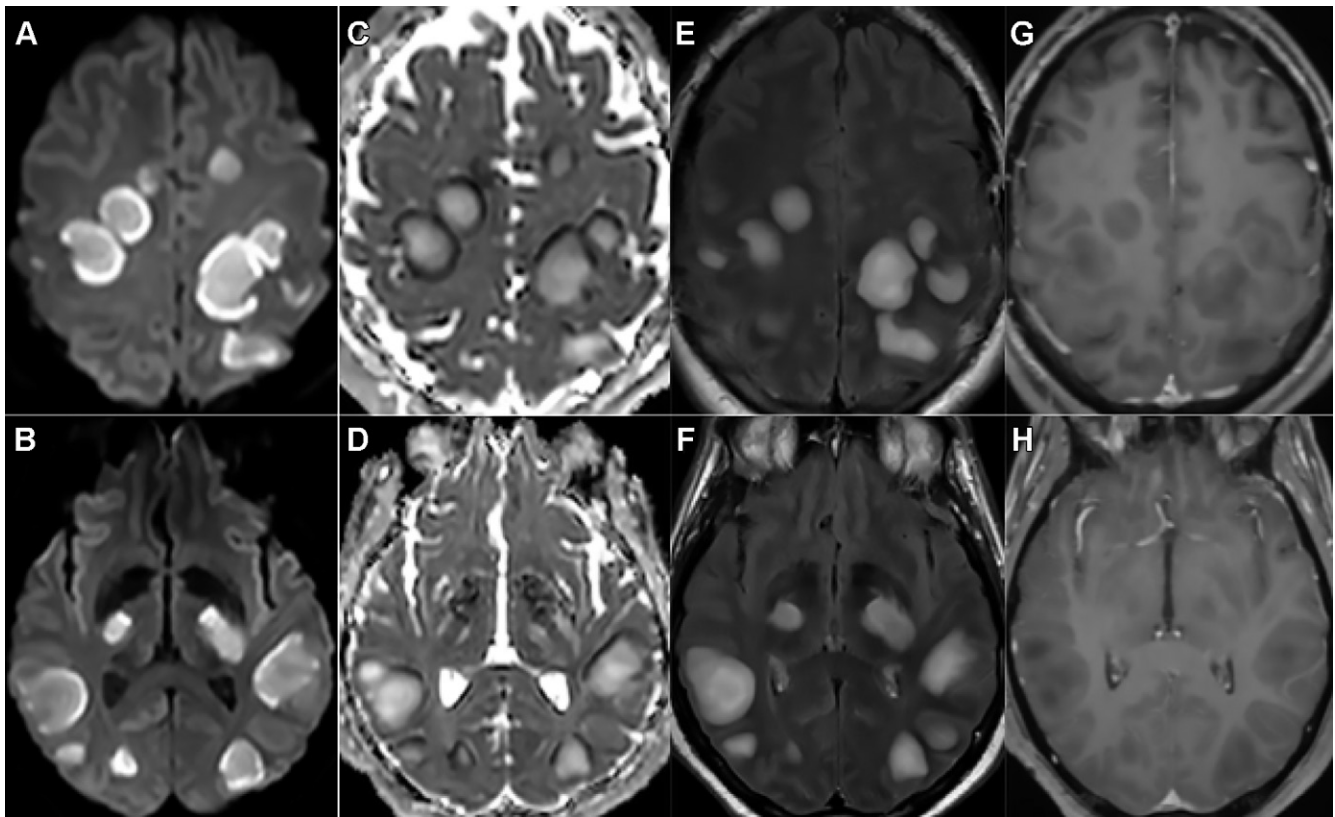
Images in a 54-year-old man with abnormal wakefulness after sedation. Nonconfluent multifocal white matter hyperintense lesions on fluid-attenuated inversion recovery (FLAIR) and diffusion-weighted images, with variable enhancement. A, B, Axial diffusion, C, D, apparent diffusion coefficient (ADC) map, E, F, axial contrast-enhanced FLAIR, and G, H, contrast-enhanced T1-weighted MRI scans. Multiple nodular hyperintense diffusion and FLAIR subcortical and corticospinal tracts lesions, with very mild mass effect on adjacent structures. C, D, The lesions present a center with an elevation of ADC corresponding to vasogenic edema and a peripheral ring of reduced ADC corresponding to cytotoxic edema. After contrast material administration, G, H, small areas of very mild enhancement are detected.
